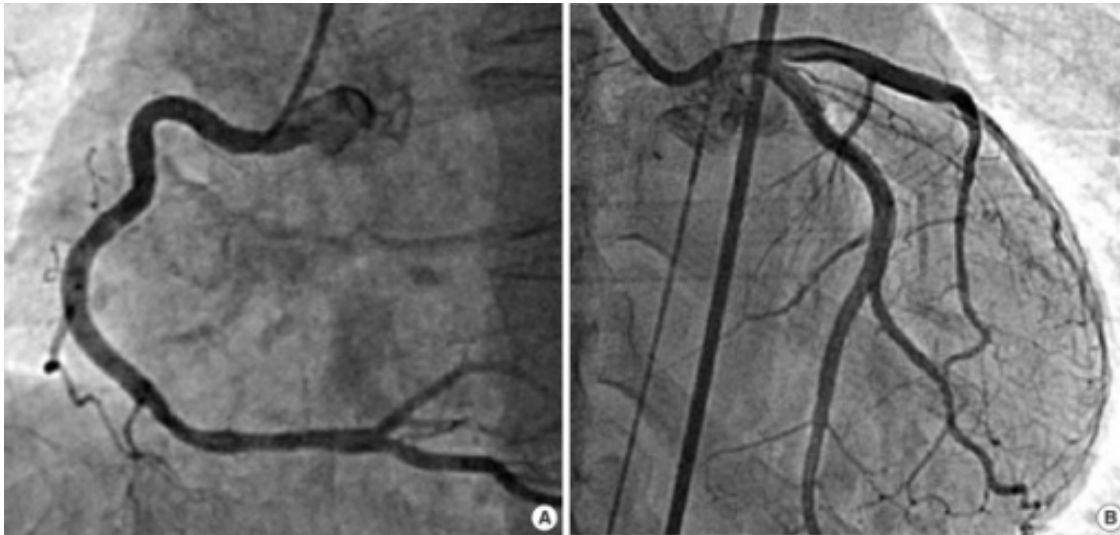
An x-ray evaluating blood flow through the coronary arteries during a coronary angiography
